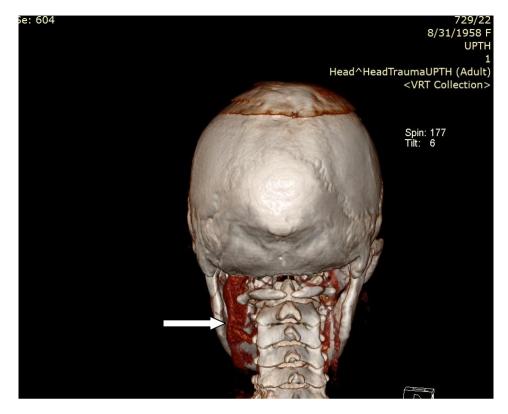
Contrast reconstructed 3-D CT showing markedly dilated and tortuous left IJV (indicated by the arrow)
